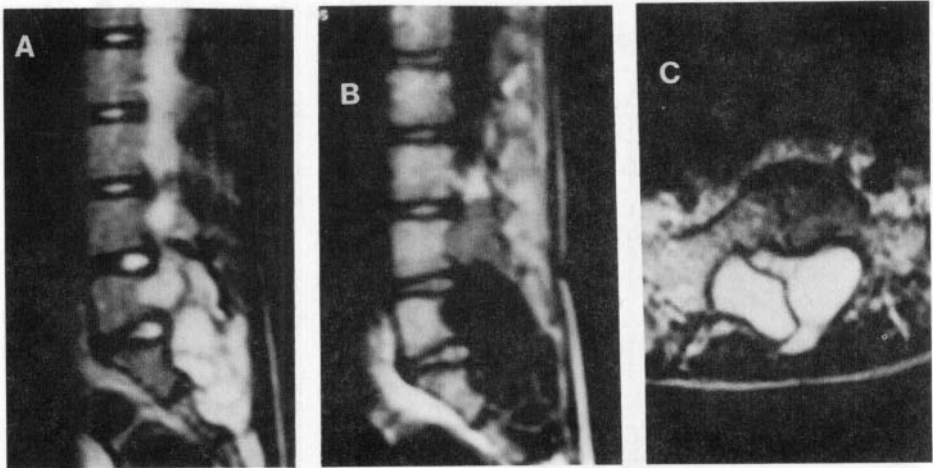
Hydatid cyst of spine. T2-weighted sagittal image (a) of the lumbosacral spine shows evidence of lobulated hyperintense area with hypointense septae in the spinal canal with scalloping of fifth lumbar to second sacral vertebrae. On T1-weighted image (b) the lesion appears hypointense with hyperintense septa. The hypointense septa are well seen in axial image (c).
